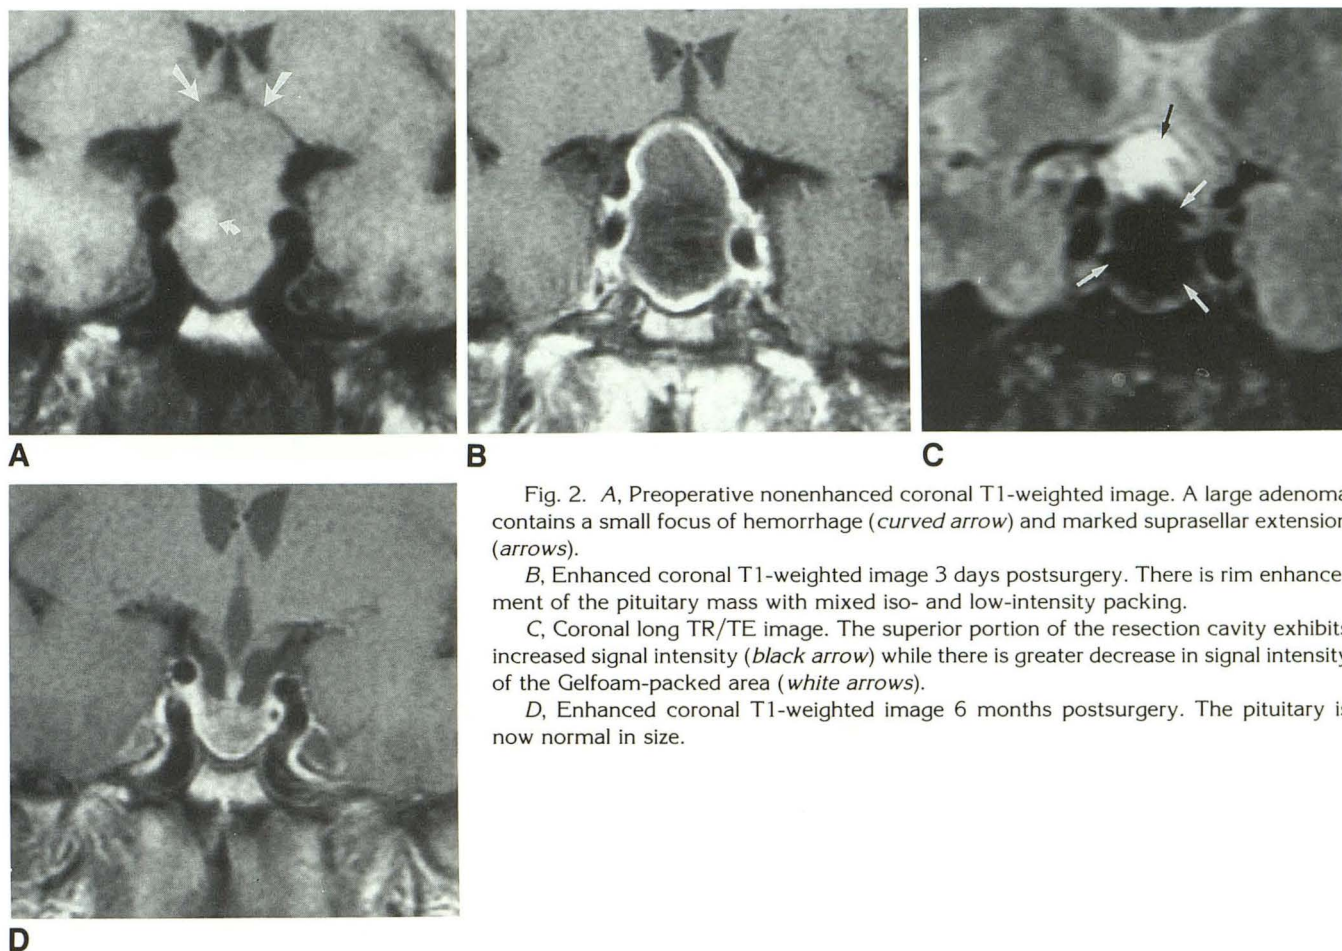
A, Preoperative nonenhanced coronal T1-weighted image. A large adenoma contains a small focus of hemorrhage (*curved arrow*) and marked suprasellar extension (*arrows*).
